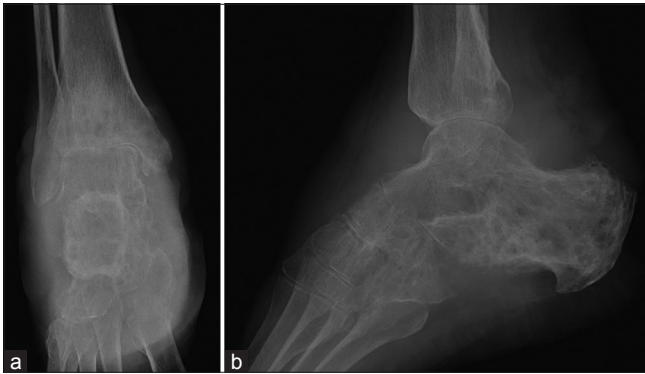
(a) Frontal radiograph and (b) lateral radiograph revealed multiple punch-out lytic areas in the tarsals with sclerosis and destruction of calcaneum. Narrowing of joint space and soft-tissue swelling was also noted.
